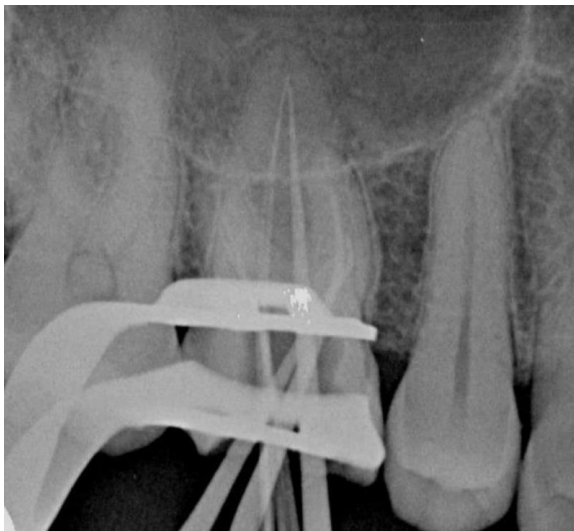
The periapical radiograph with intracanal Guttapercha cones revealing merging of two distobuccal orifices and two palatal orifices.
